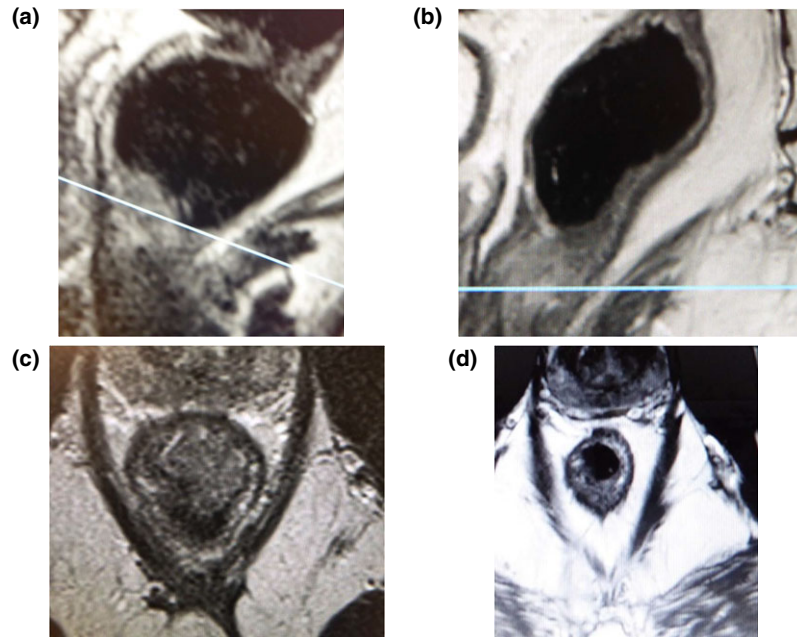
Magnetic resonance imaging response to contact X-ray brachytherapy for the same patient. (a, c) Anterior tumour in low rectum has regressed completely in corresponding views shown in (b, d).
